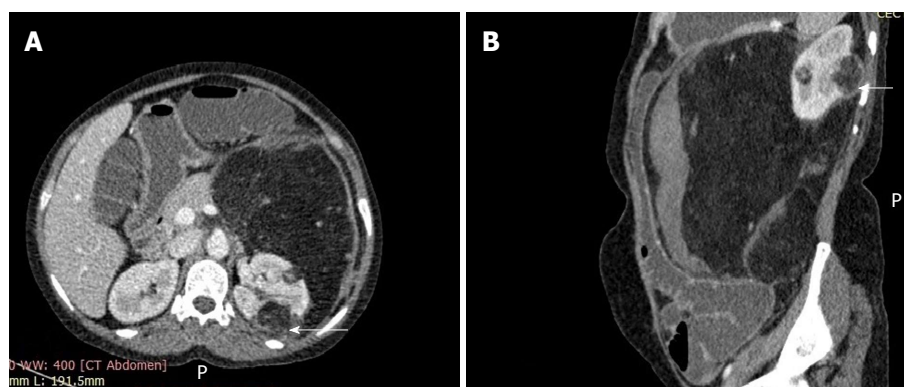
Axial section of contrast enhancement computed tomography abdomen. A: It shows two fairly well defined, predominantly fat density rounded lesions, in the left kidney. The peripheral capsule (arrow) of the smaller lesion is ill defined and continuous with a very large perirenal angiomyolipoma showing prominent vessels (+); B: Sagittal reconstruction shows a peripheral hematoma (arrow) in the perirenal lipomatous mass.
